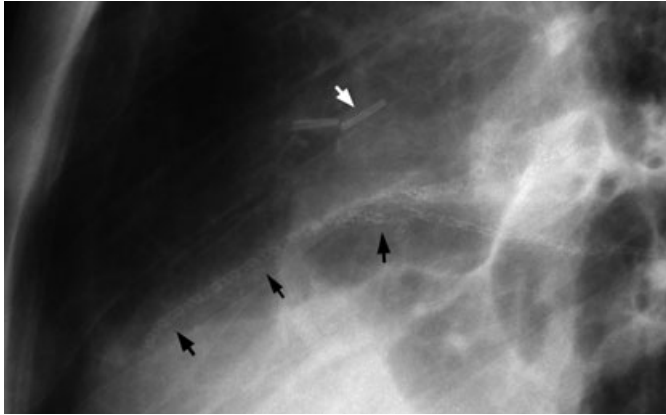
Close-up of antemortem thoracic radiograph of L.K. (anterior is to left); white arrow indicates surgical clip, black arrows indicate line of multiple internal surgical staples.
